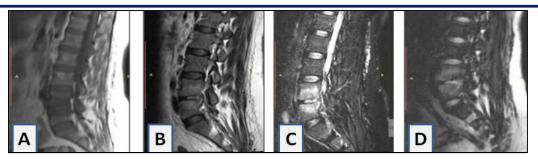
41 years old female presents with fever and back pain. A: Sagittal T1 show L4-5 endplate hypo signal intensity. B: Sagittal T2 show L4-5 endplate hyper signal intensity. C: Sagittal STIR showsL4-5 endplate hyper signal intensity. D: Sagittal DWI show L4-5 endplate diffuseabnormal signal (negative claw sign), final diagnosis was Modic 1 changes.
